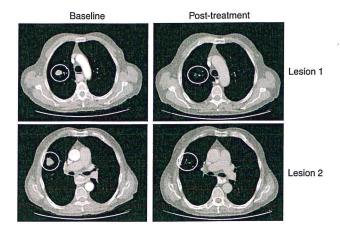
CT scan of lungs in patient ID #02-026 (metastatic adenocarcinoma of the esophagus) showing the tumor response after treatment with the combination of SGT-53 and docetaxel. Baseline: The circled areas show two individual metastatic target lesions prior to treatment; post-treatment: a significant decrease (78%) in size of both lesions is evident in this scan obtained 1 month after the end of the first round of treatment.
